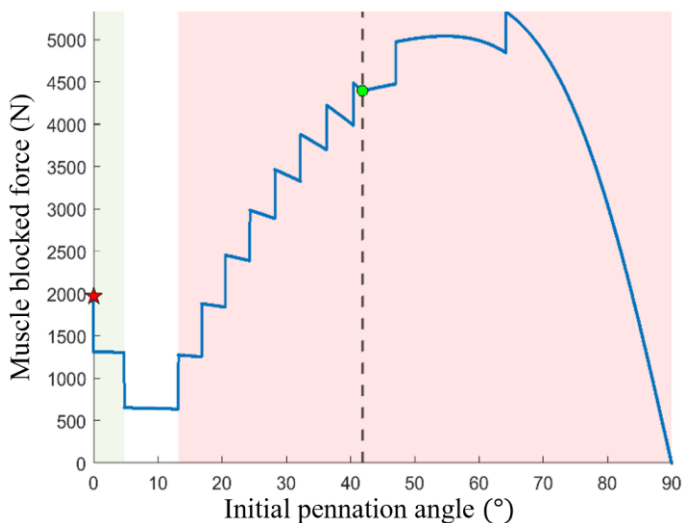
MUSCLE BLOCKED FORCE WITH RESPECT TO INITIAL PENNATION ANGLE
